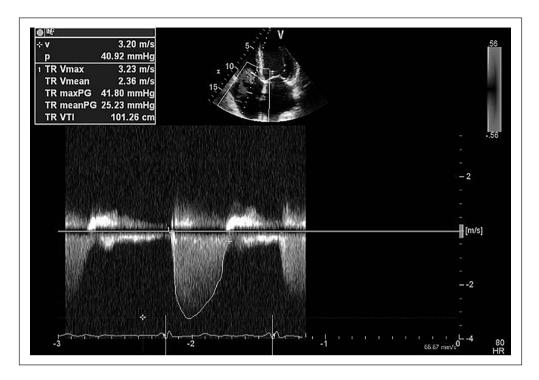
Estimation of the systolic pulmonary arterial pressure. Systolic pulmonary artery pressure can be estimated in patients having at least mild tricuspid regurgitation. The pressure gradient (difference) between the right ventricle and right atrium is a function of the regurgitation velocity (Bernoulli equation). If we add the value of the central venous pressure (measured in patients on central catheter or estimated from the size and collapsibility of the inferior vena cava by ultrasound) we get the systolic pulmonary artery pressure.
